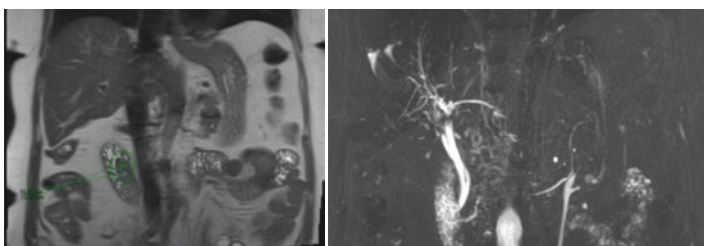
MRI/MRCP of lesion arising from the medial wall of the second portion of the duodenum without intraductal involvement
